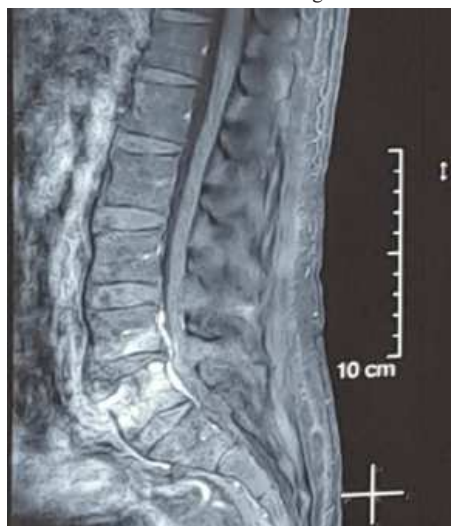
Contrast enhanced T1 sagittal MR image
